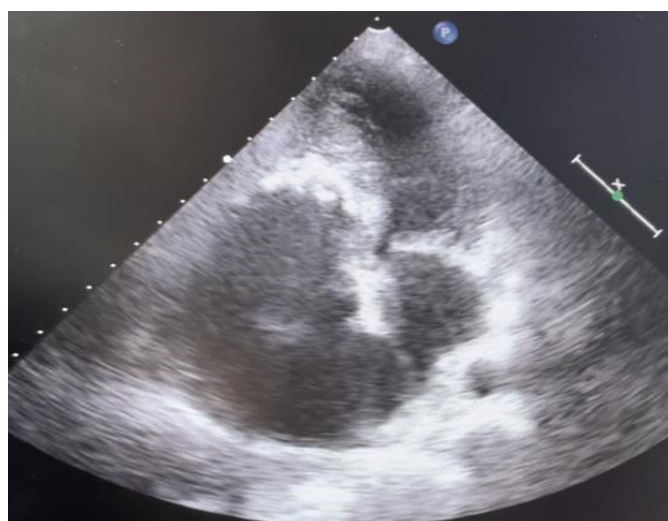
Pre operative Echocardiogram showing displaced valve and obliterated RV cavity.
